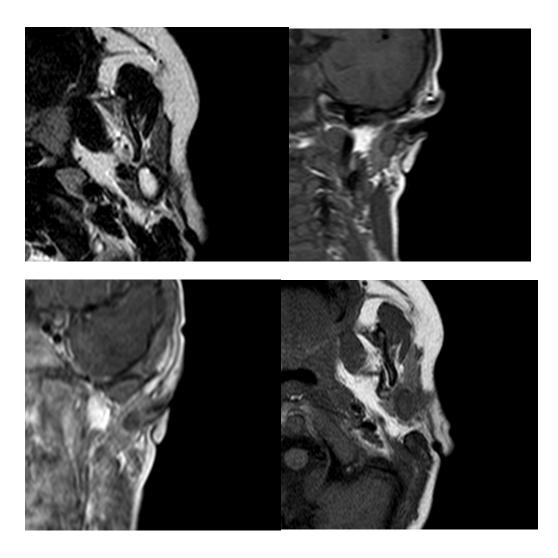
Axial T2W TSE (top left), coronal T1W TSE (top right), coronal T1 post gadolinium (bottom left), axial T1W TSE (bottom right) MRI images of patient A. MRI displays a tract (white arrow) passing posterior-superiorly into the deep lobe of the parotid and terminating in the external auditory meatus.
